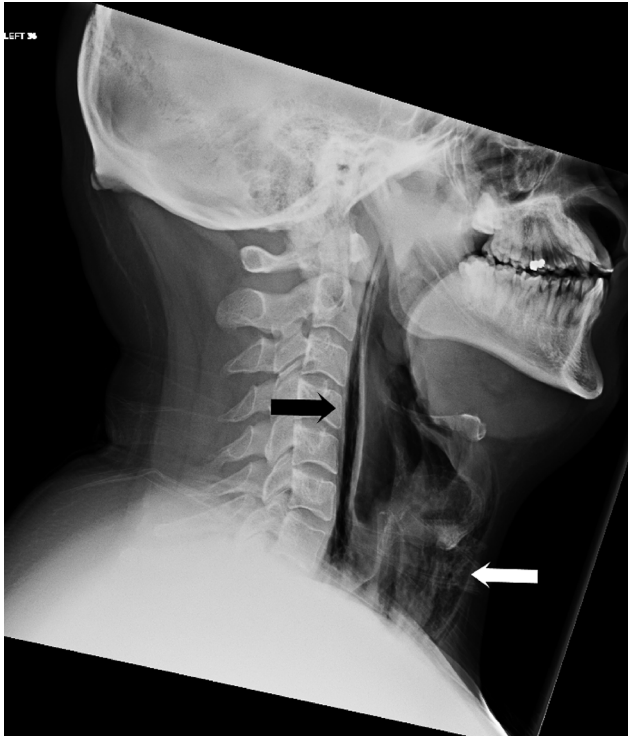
Lateral soft tissue neck radiograph with narrow window setting shows streaks of air in the retropharyngeal region (black arrow) and extensive surgical emphysema in the neck anterior to the trachea (white arrow).
